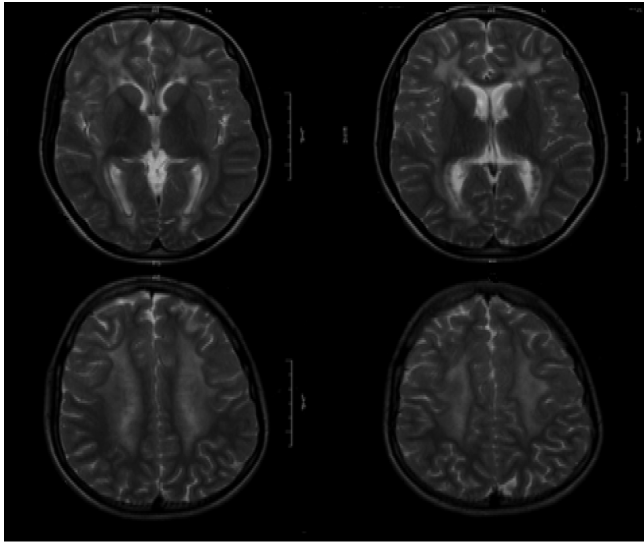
Brain magnetic resonance image of patient affected by Alexander's disease performed at age of 13. The images show bilateral and symmetrical hyperintensities on T2-weighted in white matter, with frontal predominance suggestive of the diagnosis.
